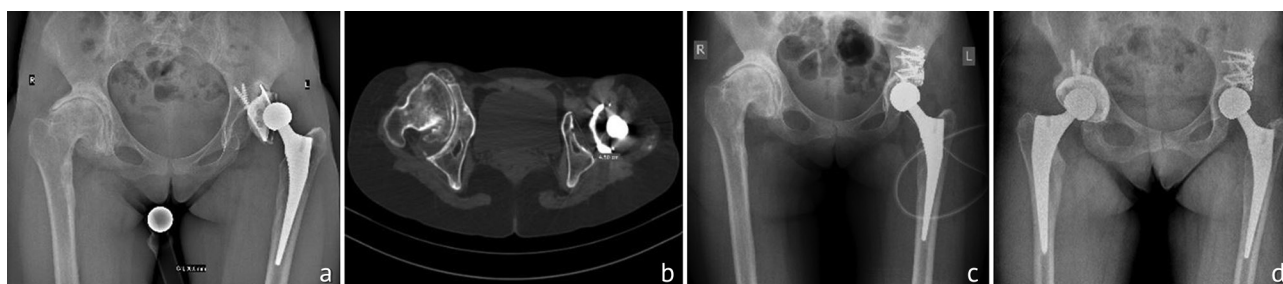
Patient B., 37 years old. X-ray findings at the main stages: *a* plain X-ray of the pelvis in a direct projection before surgery; *b* CT scan of the pelvis in the axial projection at the level of the acetabulum middle third before surgery, the transverse size of the pelvic bone is 45 mm; *c* control radiograph of the pelvis after surgery; *d* radiograph of the pelvis 5.5 years after revision arthroplasty of the left hip joint
